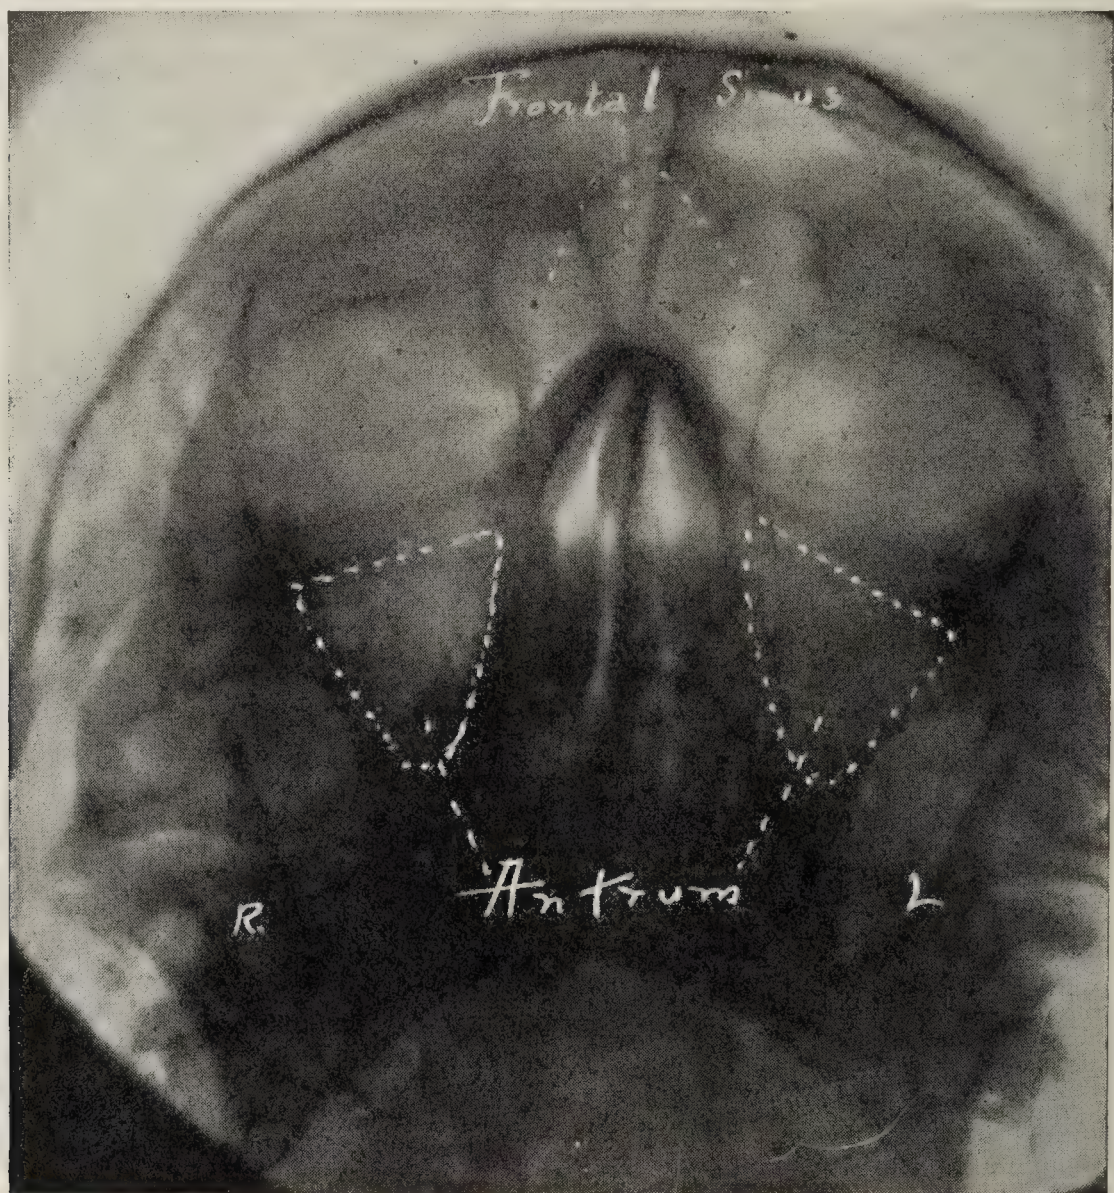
X-RAY IN A CASE OF ACUTE ARTICULAR RHEUMATISM. Right antrum partially contained purulent fluid. Patient has enjoyed health for six years following surgical treatment of the antrum.
